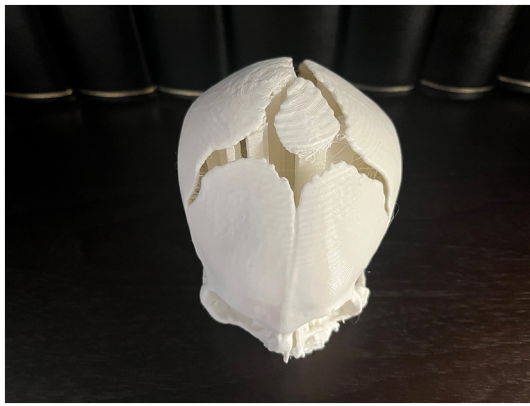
A 3D model printed from the CT scans of a child with trigonocephaly. Metopic suture synostosis is demonstrated.
